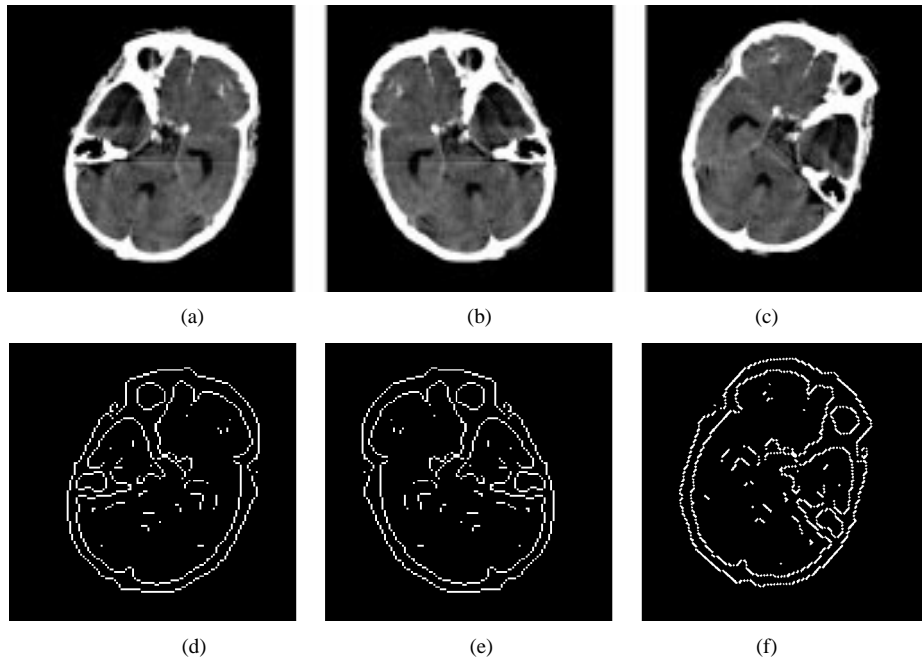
(a) A CT axial head image S_i . (b) The vertically reflected image $ref_V(S_i)$. (c) The rotated reflected image $rot(ref_V(S_i), 2\theta)$. (d)-(f) The corresponding edge images. Note that if S_i is oriented with angle θ , $ref_V(S_i)$ has angle $-\theta$, thus, we must rotate by 2θ to bring it into alignment with S_i .
